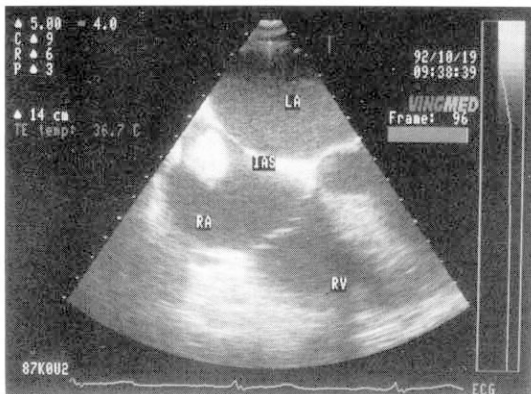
Transesophageal echocardiography demonstrates 2.5×3.5cm sized mass in the right atrium.
